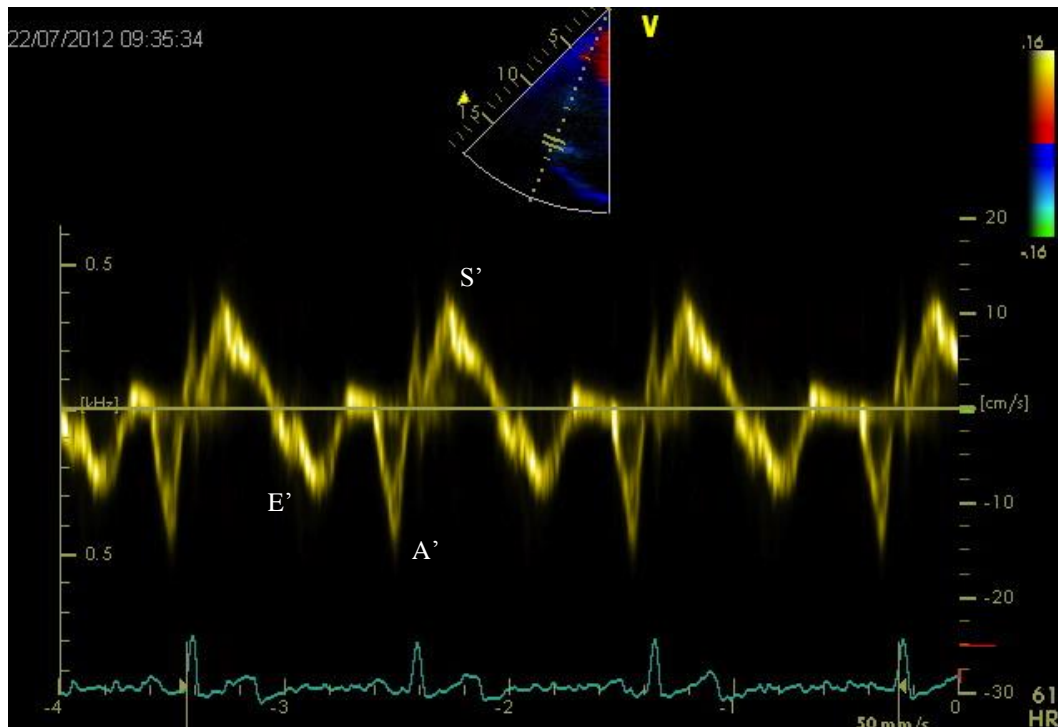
RV TDI PW Doppler of the TV annulus
